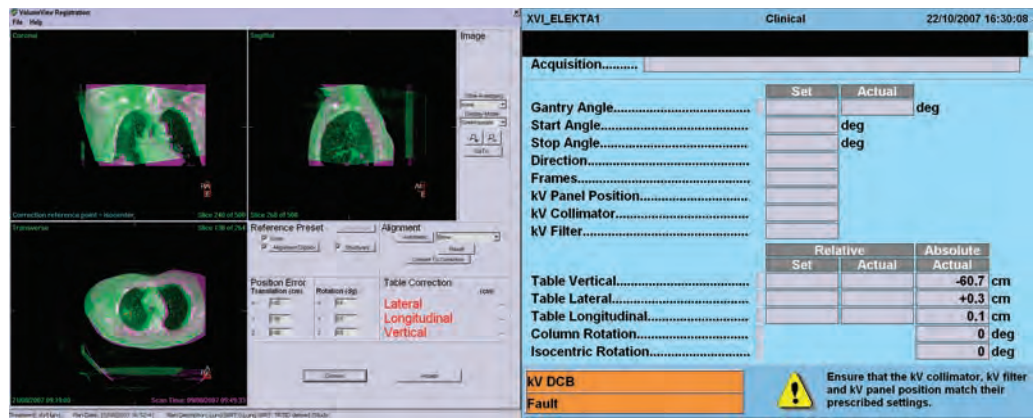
Example of kilovoltage cone-beam computed tomography images of a lung cancer patient.
